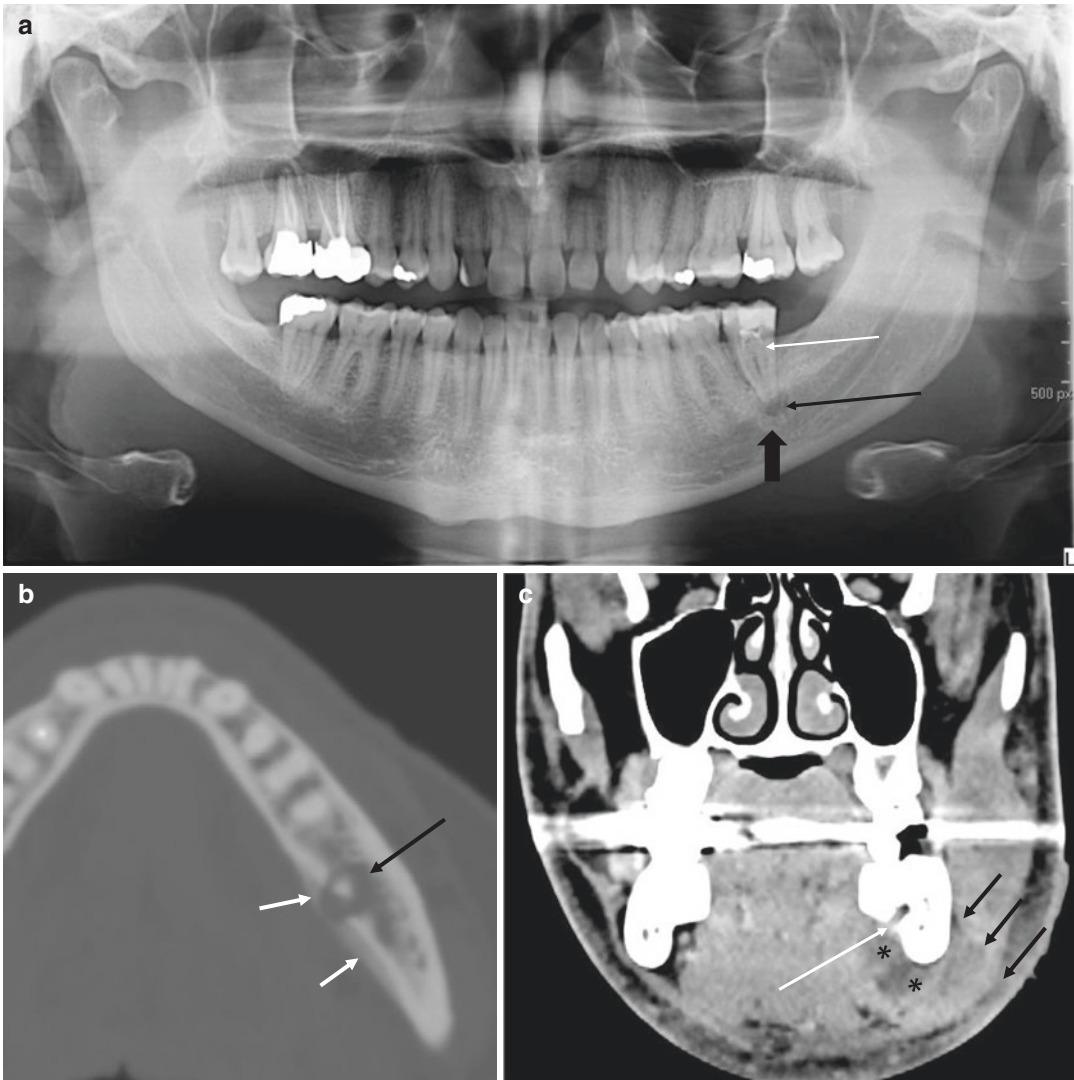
(a) Orthopantomogram showing a periapical abscess (thin black arrow) bordered by sclerosis (thick black arrow) surrounding the root of the lower left seventh molar tooth (white arrow). (b) Axial CT bone window showing periapical lucency surrounding the root of the lower left seventh molar tooth (black arrow). There is overlying periosteal reaction along the buccal cortex
